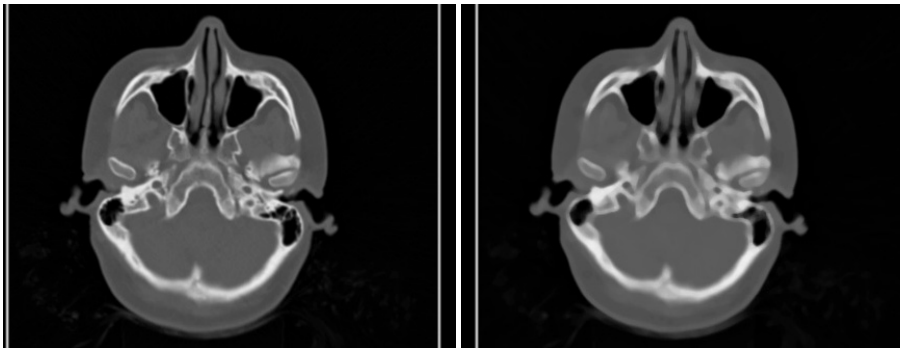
CT image of a head (left: original image, right: after applying a median filter of size  $7 \times 7$ )
